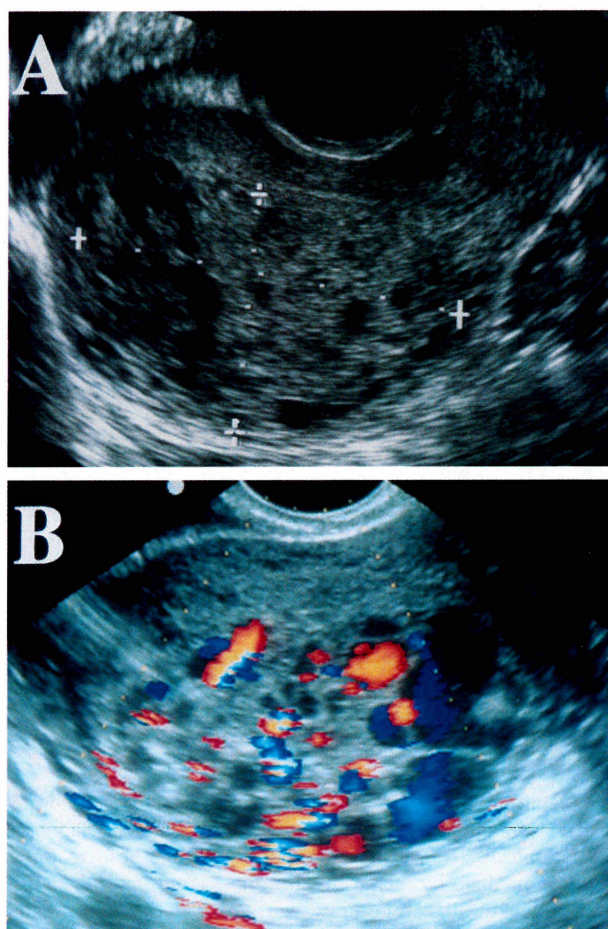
Sonographic findings for uterine tumor. (A) Pelvic ultrasonography revealed a 5.5 × 4.0 cm mass in the posterior uterine wall with multiple cystic lesions. (B) Color flow doppler image of the tumor.
